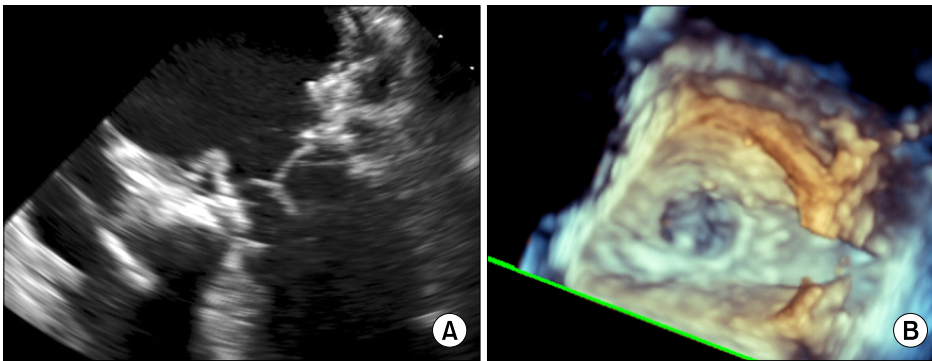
Postoperative (A) 2-dimensional and (B) 3-dimensional echocardiograms.
